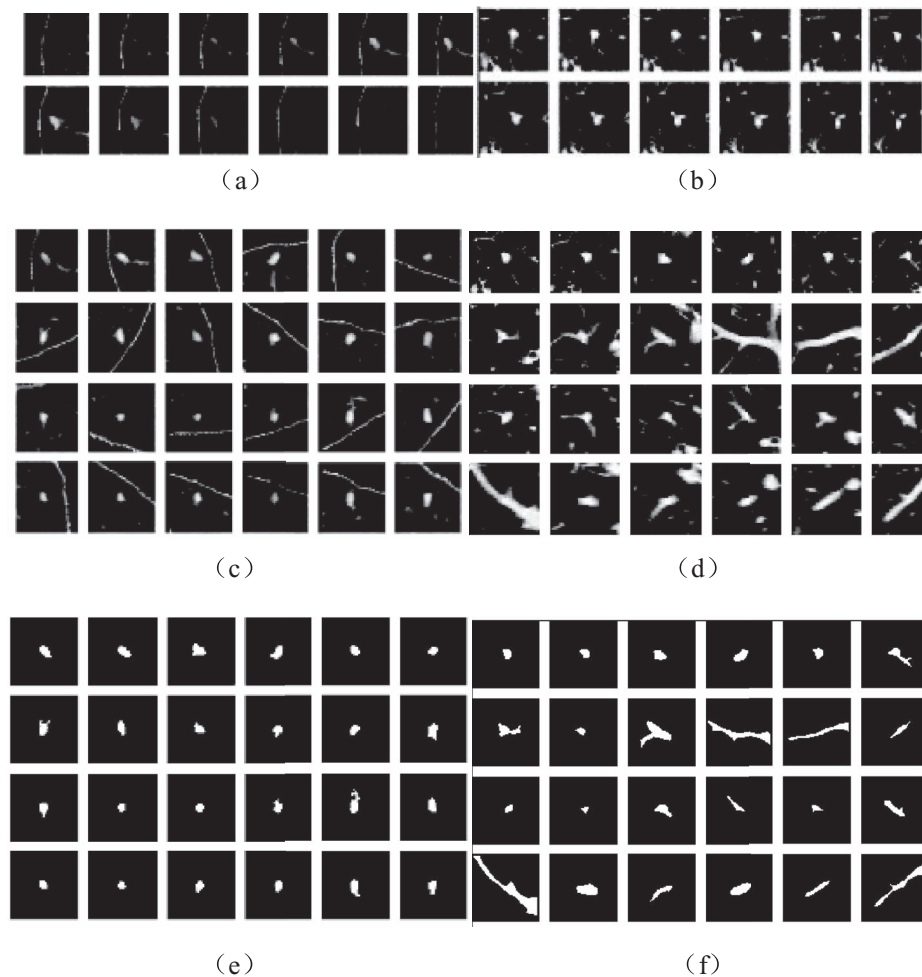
A nodule (left column) and a blood vessel (right column) in the consecutive CT slices [(a) and (b)], the 2D reformatted images [(c) and (d)], and the segmented images [(e) and (f)]. As expected, the nodule appears circular in all the consecutive CT slices and 2D reformatted images. Although the blood vessel appears as nodule-like circular objects in all the consecutive CT slices, it appears clearly as noncircular linear structures in some “effective” 2D reformatted images. These “effective” 2D reformatted images enable us to well distinguish nodules from blood vessels.
